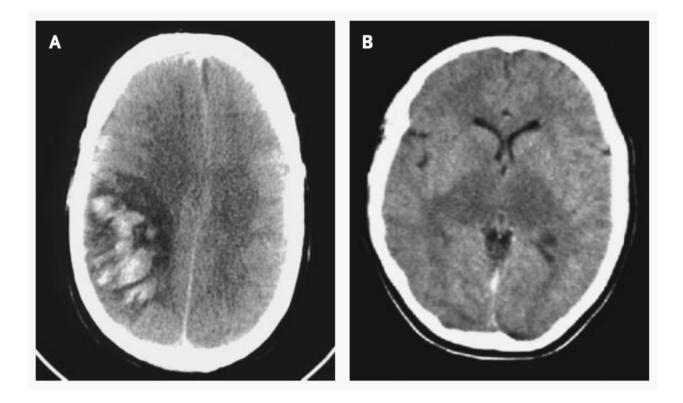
CT Imaging of Sinus Thrombosis.
